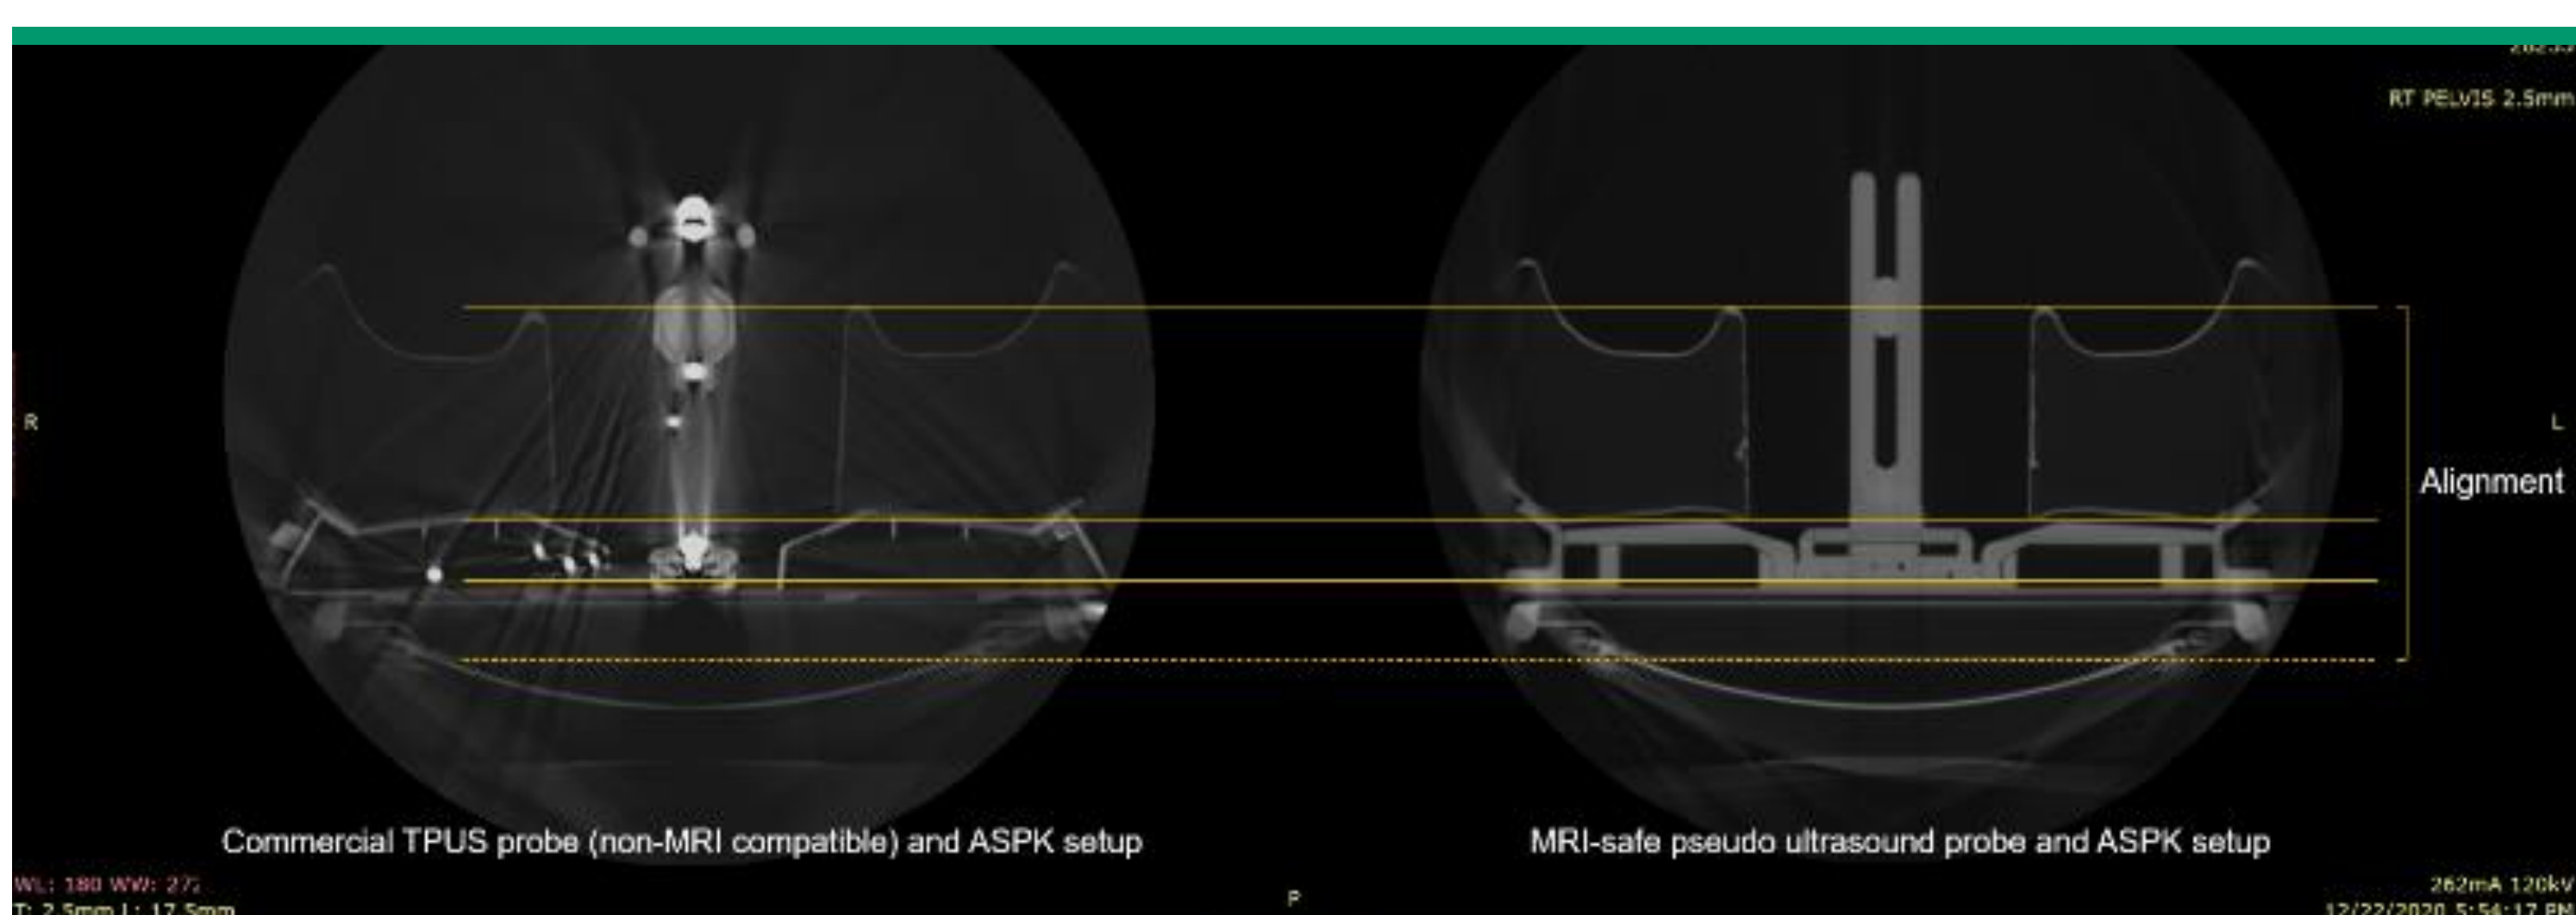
CT scan of final device vs commercial TPUS probe setup (Material passed MRI image test, accuracy and precision in dimension)
